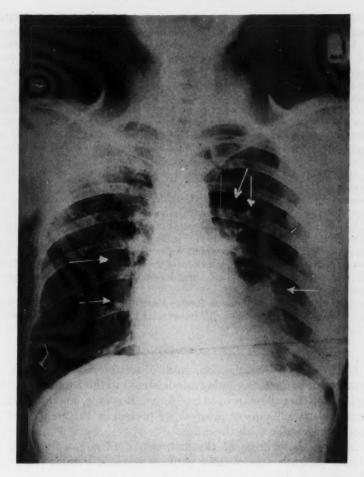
This roentgenogram was made nine weeks after the preceding one. In the interim the patient had received 6400 mg. of testosterone propionate. The metastases in both lung fields have diminished in size and number.
